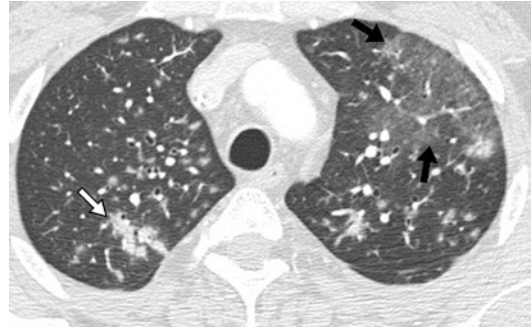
A 44-year-old man with respiratory syncytial virus (RSV) infection and peripheral T-cell lymphoma. CT scan shows multiple bilateral ill-defined nodular opacities. Note a ground-glass opacity in LUL (black arrows) and a focal consolidation in RUL (white arrow)
